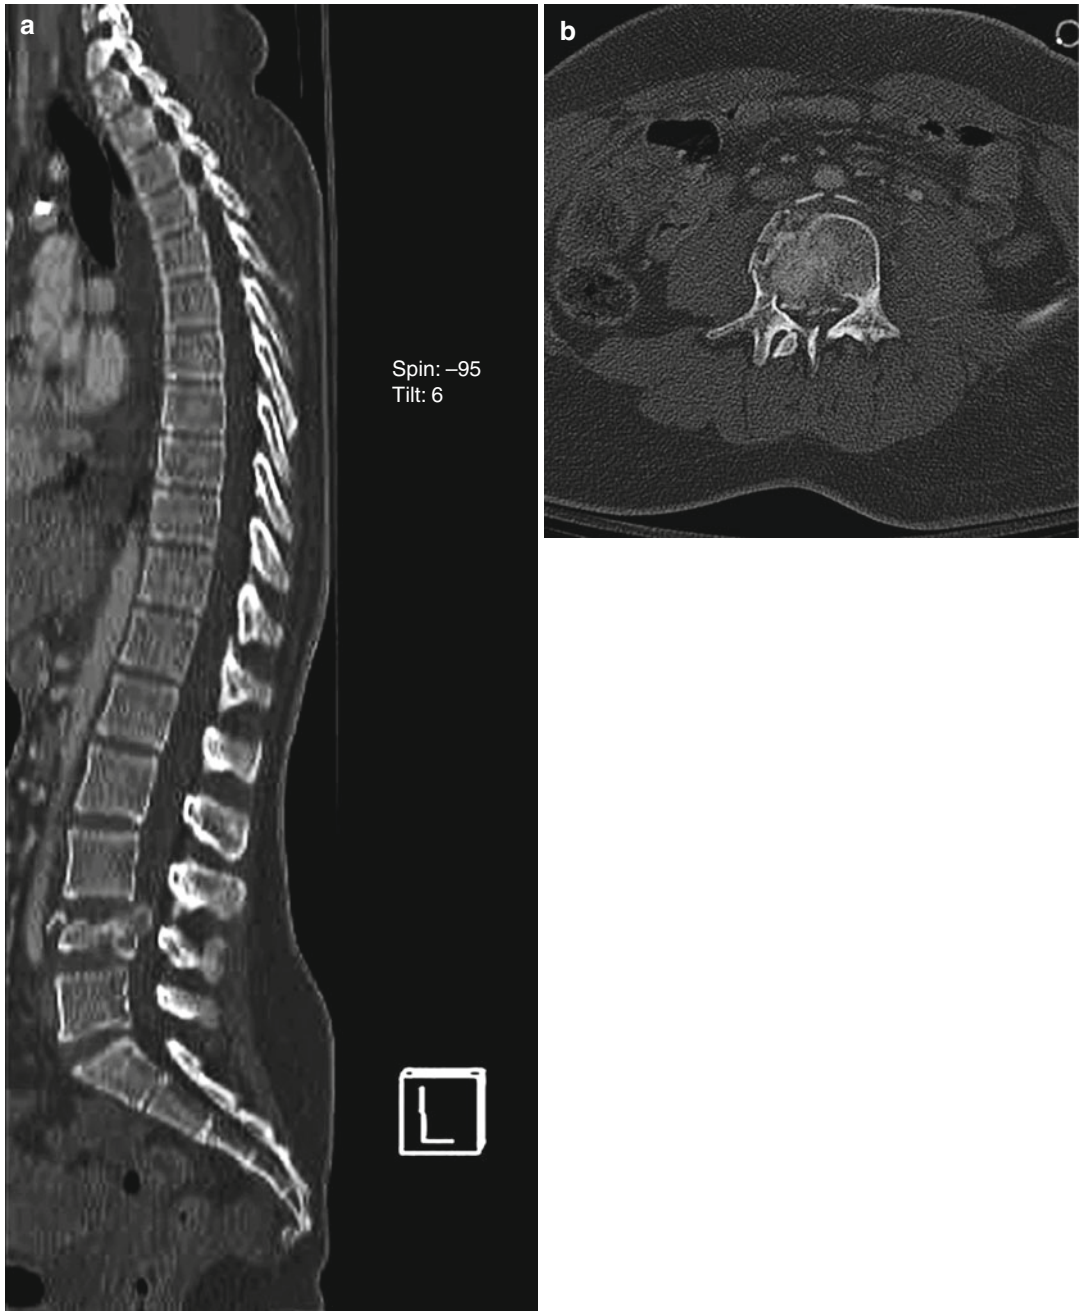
(a) Midsagittal and (b) axial CT views showing L4 burst with more than 50 % vertebral body weight loss, 70–80 % canal compromise, and loss of normal lumbar lordosis
